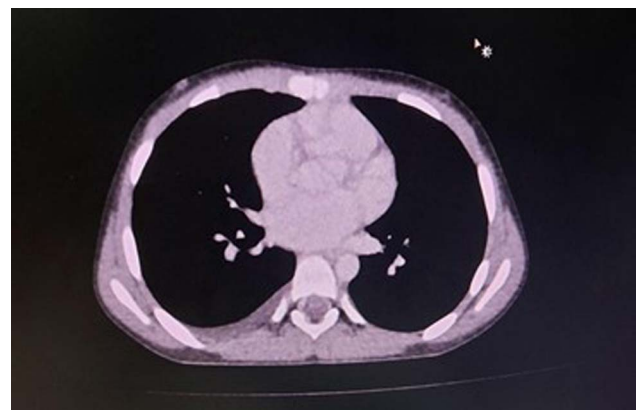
Computed tomography scan of the chest showing pleural effusion.
